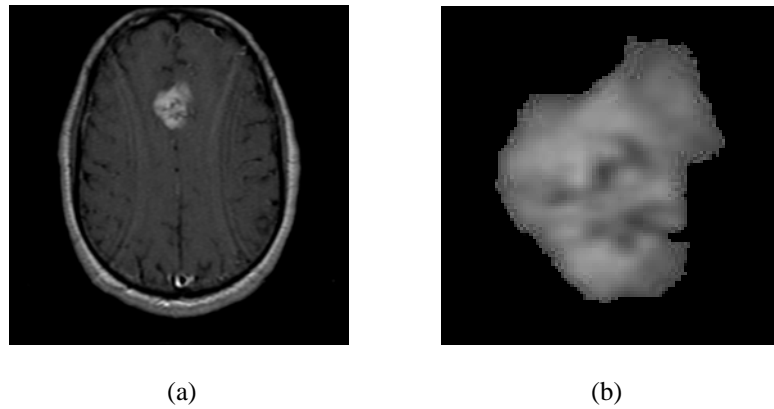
(a) An original 2D axial MRI slice and (b) the segmented tumor (ROI) obtained using fuzzy-connectedness segmentation
